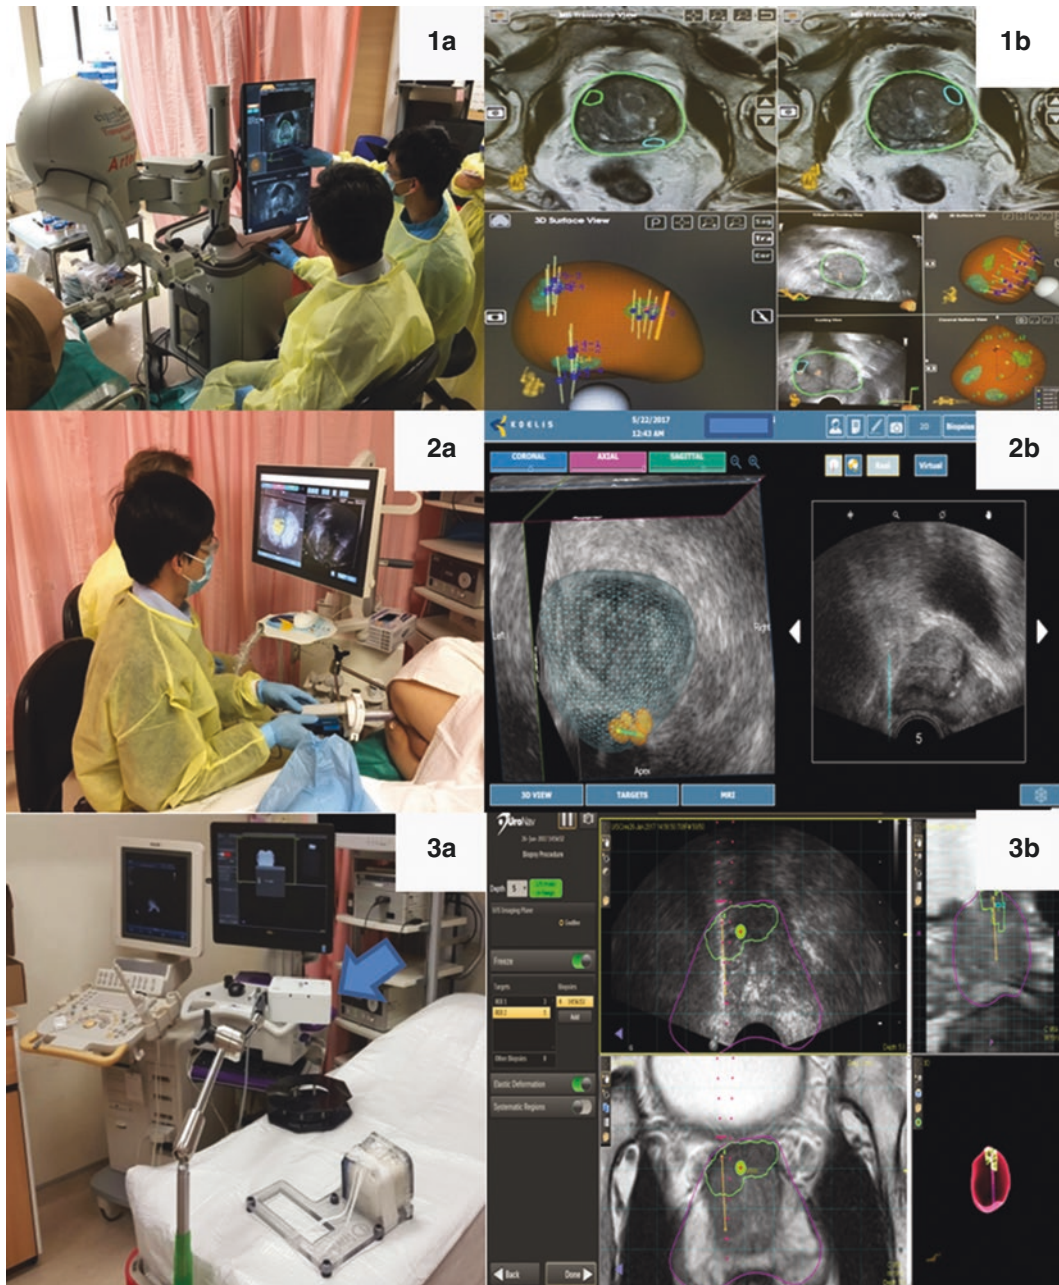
Fusion biopsy machines with different needle tracking mechanisms (1a, 2a, 3a, 4a) and respective screen shots during fusion biopsy done under local anaesthesia (1b, 2b, 3b, 4b). 1a, Robotic arm with sensor encoded joints (Artemis, Eigen), require additional ultrasound machine; 1b, Green line (prostate border on MRI) overlaps with real-time ultrasound using elastic fusion, and target lesion reached with rotation of robotic arm over a fixed axis; 2a, Image based tracking (Trinity, Koelis) with intrinsically incorporated ultrasound, and option of mechanical probe holder (Steady Pro); 2b, Elastic fusion, Needle path of a biopsy core targeting a very apical lesion; 3a, Electromagnetic tracking (Uronav, Invivo/Philips) with magnetic field generator (blue arrow), require additional ultrasound machine; 3b, MRI prostate border (purple) and Biopsy needle track going right through an anterior lesion (green); 4a, Electromagnetic tracking (Virtual Navigator, Esaote) with intrinsically incorporated ultrasound, and magnetic field generator (blue arrow); 4b, MRI image (yellow shadow) overlapping on a ultrasound image of slightly deformed prostate with transrectal probe in-situ. Anatomical landmarks (bladder neck, rectum, pubic bone, urethra) needed to facilitate manual rigid fusion
